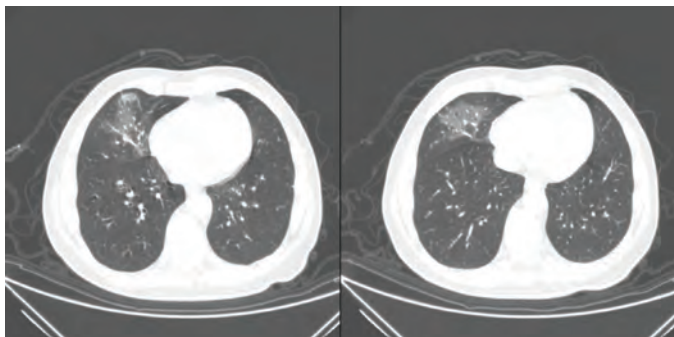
Thorax computed tomography of the patient on the day of admission
